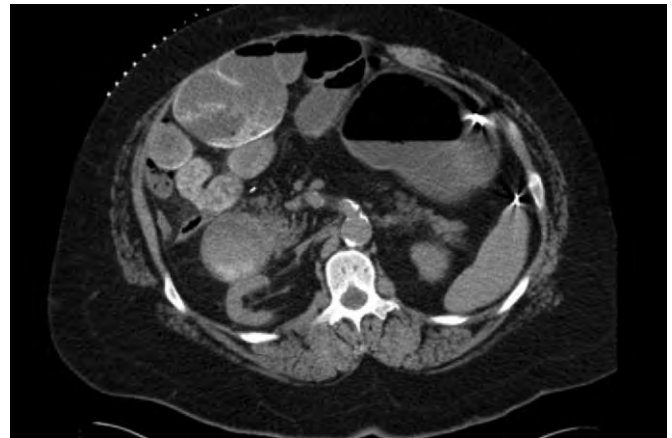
Computed tomography scan of the upper abdomen showing dilated loops of proximal small bowel with air-fluid levels adjacent to less dilated, more distal loops of small bowel.
